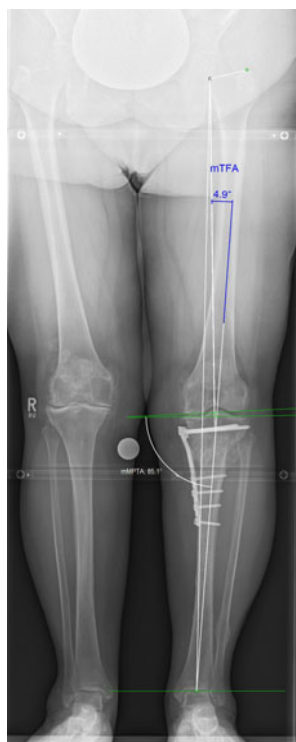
Full-weight bearing long-standing anteroposterior radiograph of the whole lower extremity
